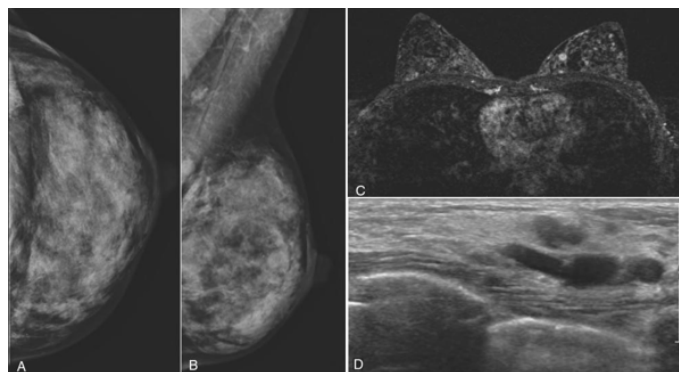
High risk 53-year-old patient breast images. A and B: normal left mammogram; C: MRI at 6-month interval revealed a 7-mm mass; D: Targeted USG finds a left 9 o'clock abnormality (Kuhl and Mahoney, 2013).
